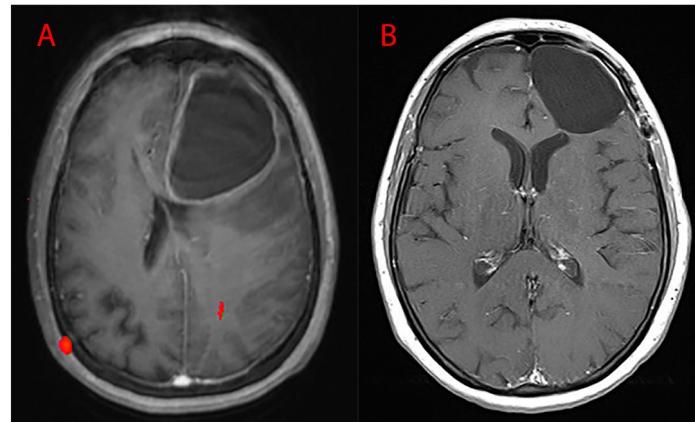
MRI T1WI axial section. (A) preoperative left parieto-occipital Glioblastoma (B) post-operative images (absence of residual disease-GTR).
